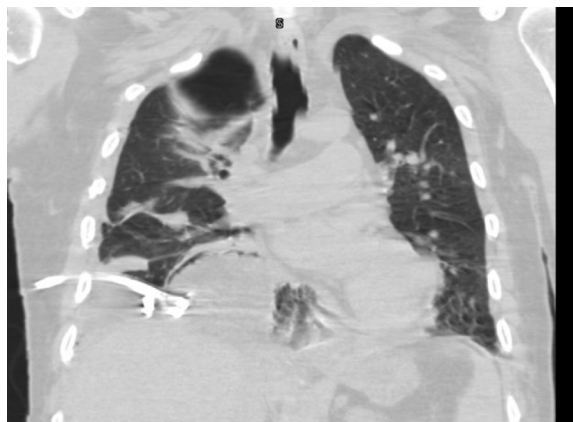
CT scan of the chest showed multiple right sided loculated pleural effusions with air-fluid levels.
